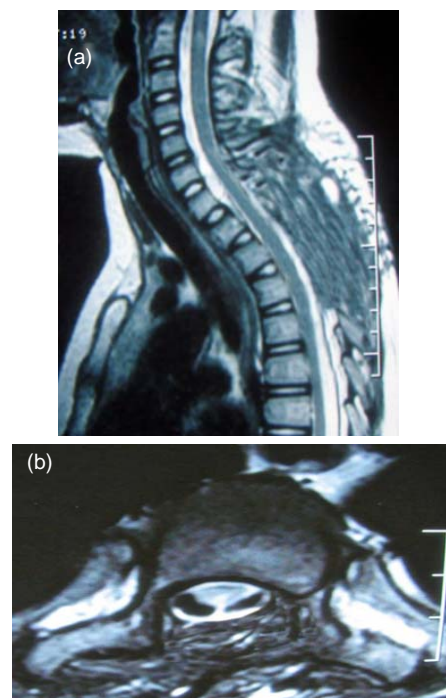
Postoperative T2-weighted magnetic resonance images show that the intrathoracic meningocele and intraspinal arachnoid cyst have disappeared and there is minimal kyphoscoliosis of the spinal column
